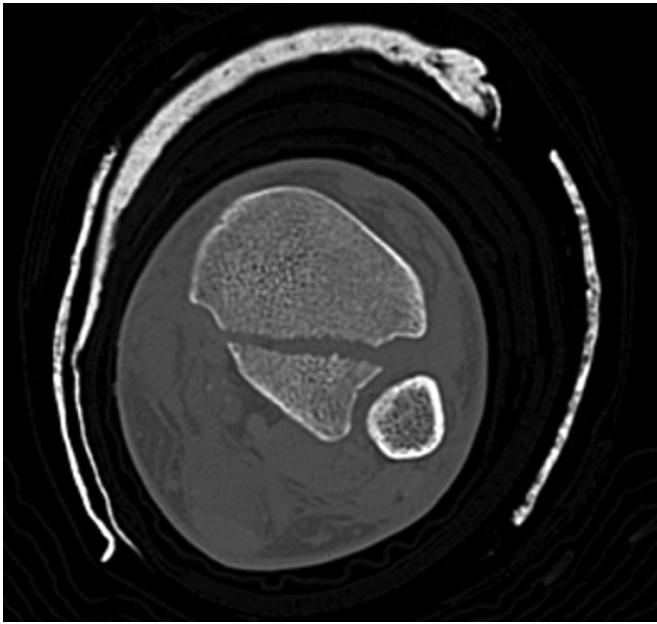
Computed tomography classification of posterior malleolar fractures. Haraguchi et al (20) proposed a descriptive classification system for posterior malleolar fractures using computed tomography findings. In their study, most posterior malleolar fractures (67%) were so-called type 1 injuries involving a triangular-shaped fragment of the posterolateral corner of the tibial plafond, including the posterior tubercle of the incisura fibularis and posterior inferior tibiofibular ligament. They also reported that the mean angle between the primary fracture line and the bimalleolar axis was $20.9^\circ \pm 9.4^\circ$ (20).
